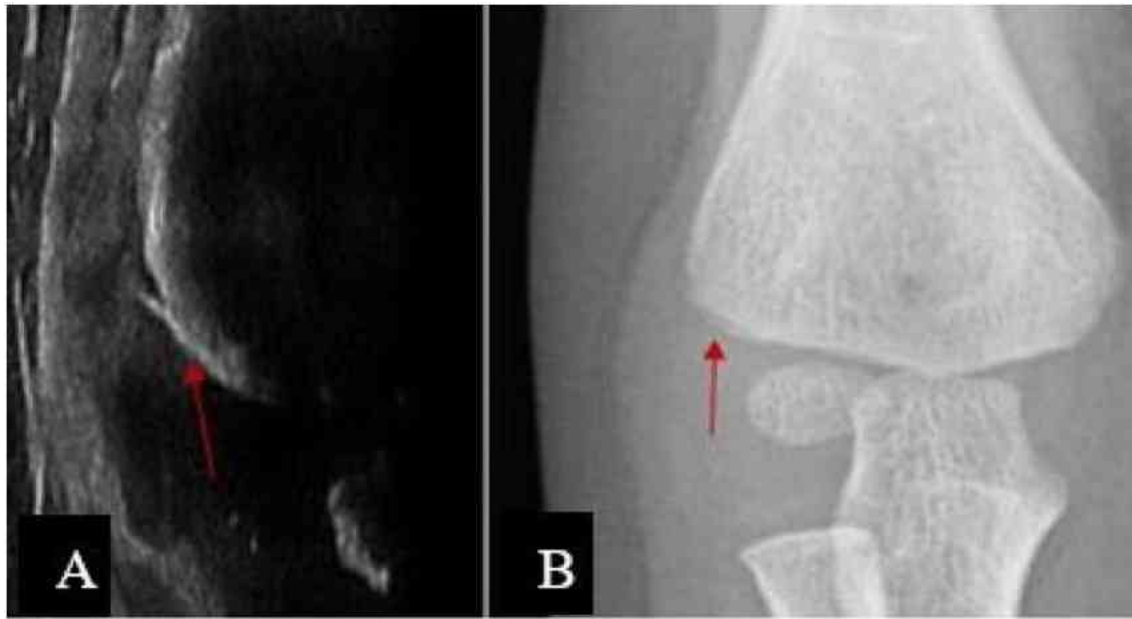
Anteroposterior X-ray and ultrasound picture of a radial condyle fracture in a 6 years old child. Signs of cortical disruption.
